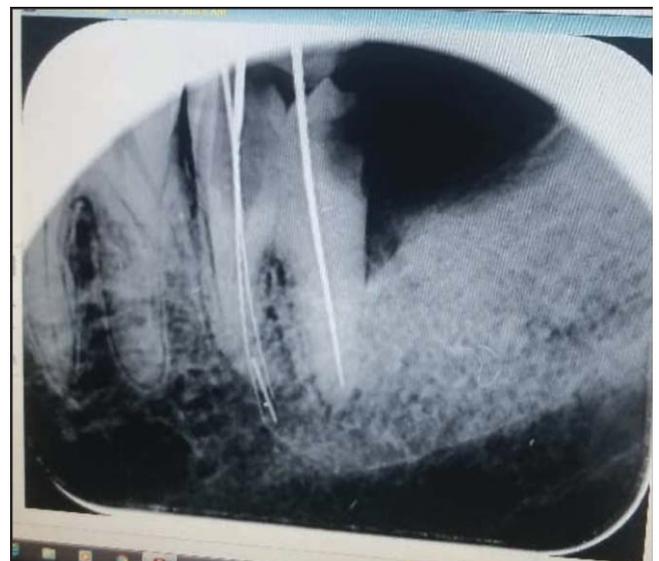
Periapical radiograph showing the separated instrument in the mesiobuccal root being by-passed by #10K file.
